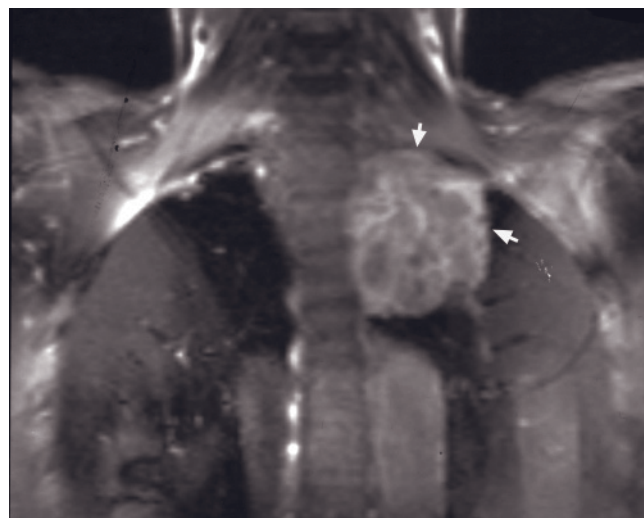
Pancoast tumor. Coronal T2-weighted ETSE (a) and coronal (b), transverse (c), and sagittal (d) T1-weighted postgadolinium fat-suppressed 3D-GRE in patient with Pancoast tumor (arrows, a, b, d). Coronal (e) and transverse (f) T1-weighted
